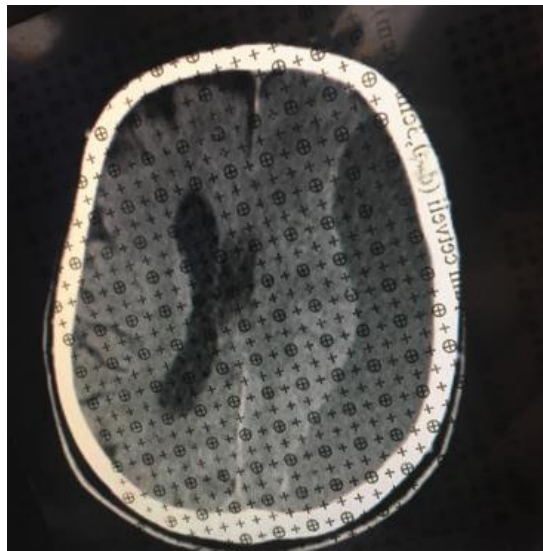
The common point counting grid (CPCG) superposed over the computed tomography images. Intracranial structure and hematoma areas in the images of each patient were counted.
